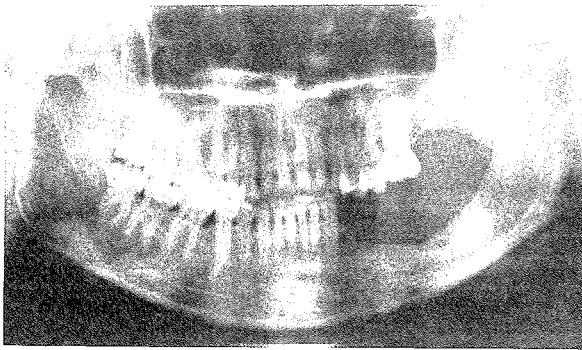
18 months post-operative radiograph showing good bony deposition in the region of the mandible from which the ameloblastoma was removed (Case 2).
